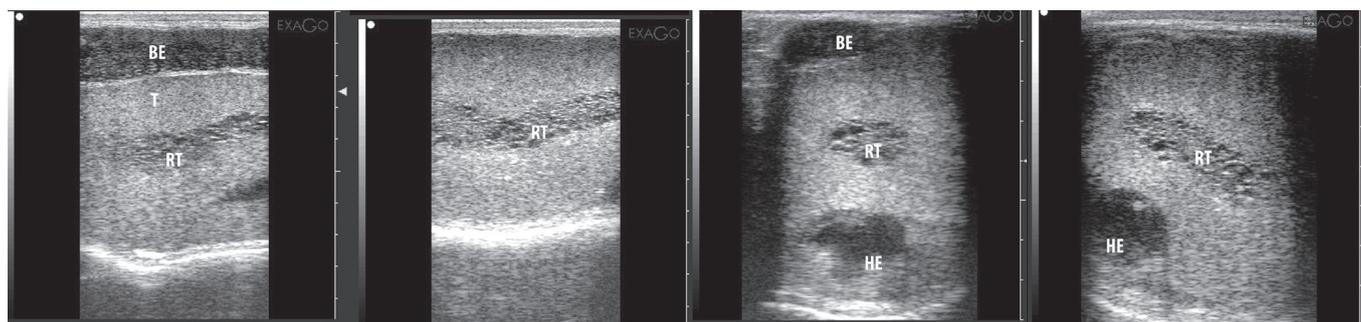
Ultrasonogram of a ram testis with dilated rete testis (cystic rete testis) due to spermastasis in the head of the epididymis. BE= Body of the epididymis, T= testis, RT= rete testis, HE= head of the epididymis
